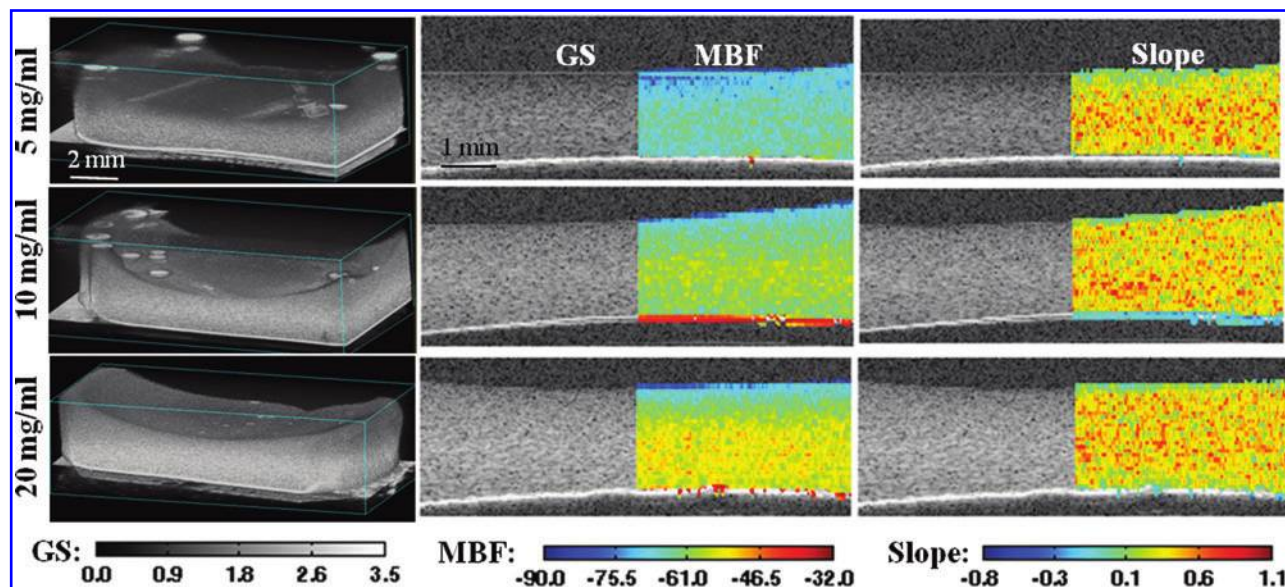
Ultrasound imaging of collagen-HA constructs made with three different concentrations of HA-N with sonication. First column shows 3D rendered images, second column shows GS and superimposed MBF, and third column shows GS and superimposed slope. Rows show the HA-N concentration used to make the constructs. Color images available online at www.liebertpub.com/tec
